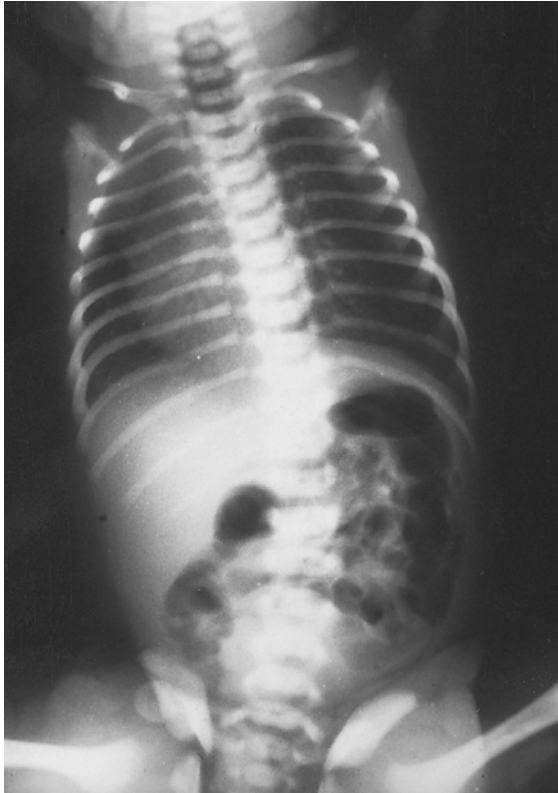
Plain x-ray of the chest and abdomen shows air in the oesophageal pouch, stomach and small bowel, indicating that there is a distal tracheo-oesophageal fistula.
